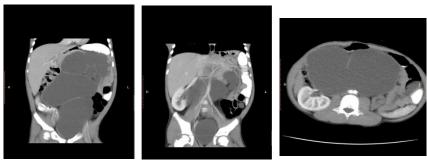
Abdomen CT Scan with Contrast
